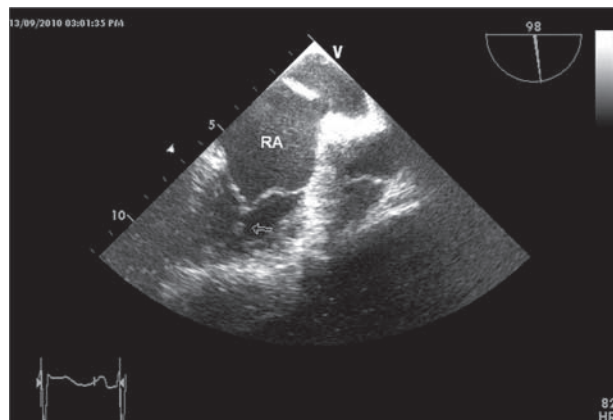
Trans-oesophageal echocardiographic view at 98#. Anterior and posterior tricuspid leaflets are attached to a single short papillary muscle (arrow). Note a small secundum atrial septal defect. RA: right atrial.
